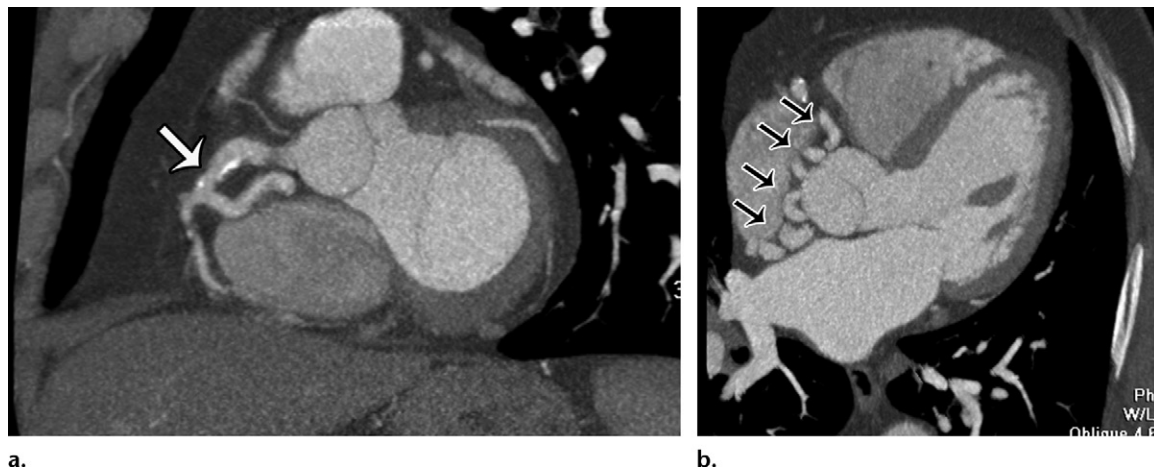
CAVF terminating in the right atrium in a 27-year-old woman. (a) Curved planar reformatted image from coronary CT angiography demonstrates that the fistula arises as a branch from the proximal RCA. Calcifications (arrow) within the RCA were presumed to be related to a high-flow high-pressure state secondary to the fistula. (b) Axial image from the same study shows that multiple tortuous dilated vessels (arrows) are present.
